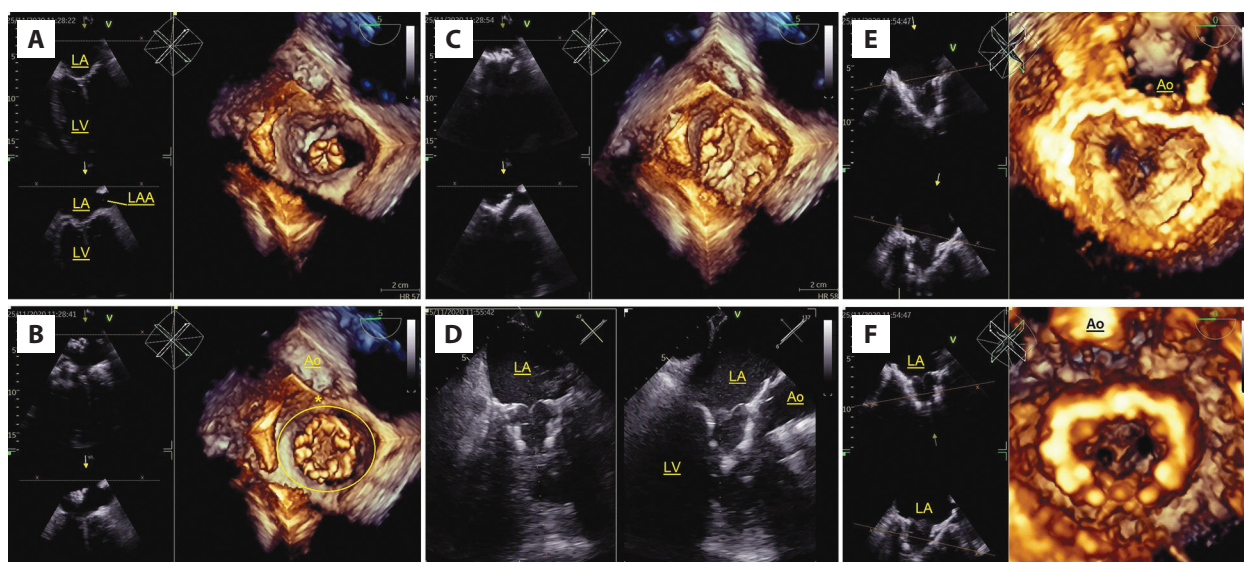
A. Transesophageal echocardiography, biplanar imaging, obtained from inter commissural view showing the Tendyne valve partially deployed within the mitral annulus. B. 3D transesophageal echocardiography surgeon's view, showing sheath positioning (asterisk showing the part facing LVOT; circle showing the D-shape of the valve). C. 3D transesophageal echocardiography en face (surgeon's view). Valve clocking (determining the radial orientation of the valve) should be performed to align the anterior cuff of Tendyne with A2 scallop, along the anterior atrial wall and behind the aortic valve. D. Transesophageal echocardiography, orthogonal biplanar imaging obtained from inter commissural view (left panel) showing the correct valve seating with no residual motion of the prosthesis and no LVOT obstruction (right panel: long axis view). E. 3D transesophageal echocardiography en face (surgeon's view) — the final result. F. 3D transesophageal echocardiography ventricular view showing the final result
